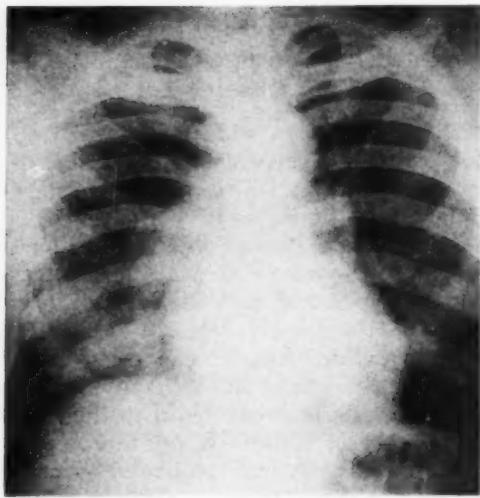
Roentgenogram of the chest taken on the third day of illness, showing the early changes of hemorrhagic fever with dilatation of the pulmonary vessels and widening of the heart shadow.
